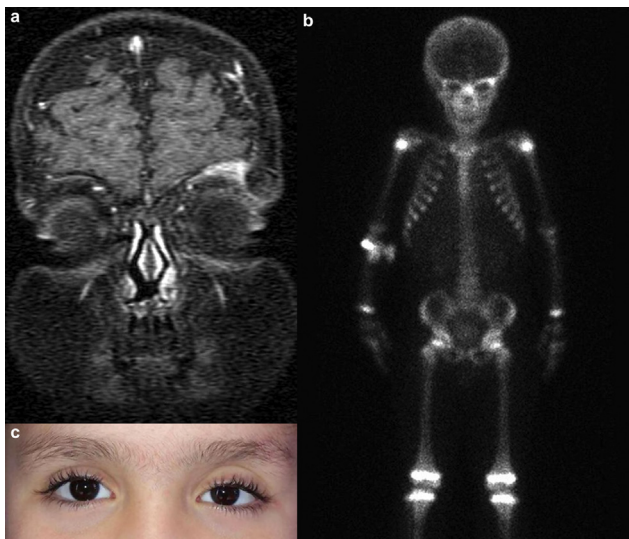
5-year-old boy with eosinophilic granuloma of the left orbit. (a) T1 weighted magnetic resonance imaging shows a 16×10 mm lesion affecting the upper wall of the left orbit with contrast enhancement after gadolinium injection. (b) Whole body bone scintigraphy shows increased focal osteoblastic activity in the upper lateral aspect of the left orbit. (c) Facial photograph at 3 years follow-up status post orbitotomy, subtotal tumor excision, and systemic chemotherapy shows no residual or recurrent disease.
